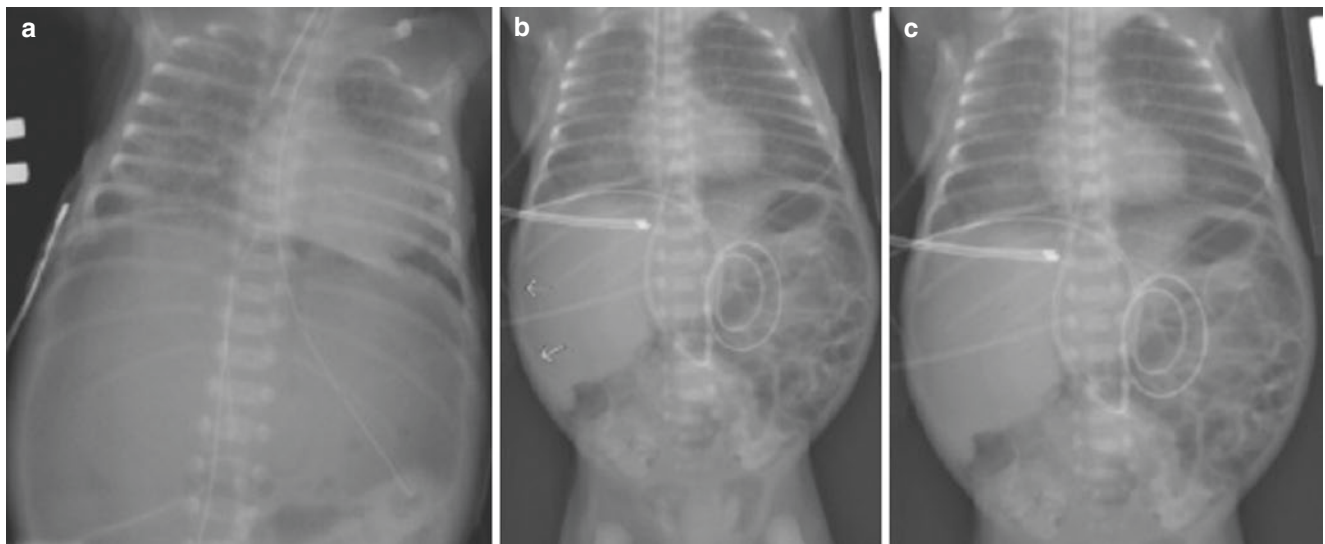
(a) Supine radiograph with a large pneumoperitoneum, (b) the lateral extent of this relatively subtle pneumoperitoneum is indicated by the *arrows*, (c) same image as (b) without the *arrows*
